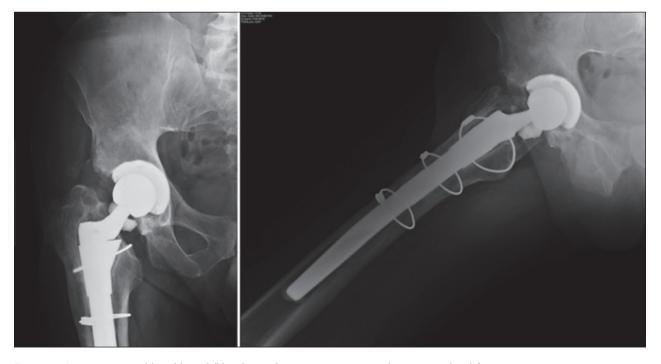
Anteroposterior (a) and lateral (b) radiographs at presentation revealing ceramic head fracture
